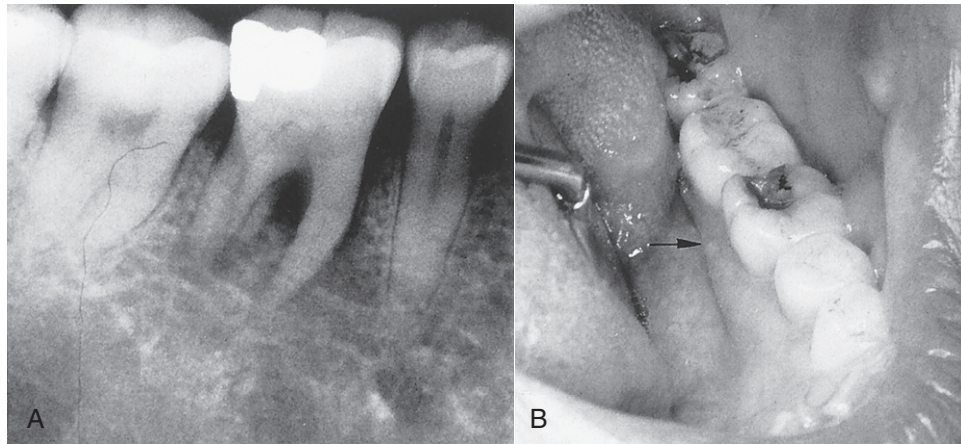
A, Radiograph showing periapical radiolucency associated with parulis shown in B. B, Fracture of distolingual cusp related to undermined tooth structure and amalgam restoration.
